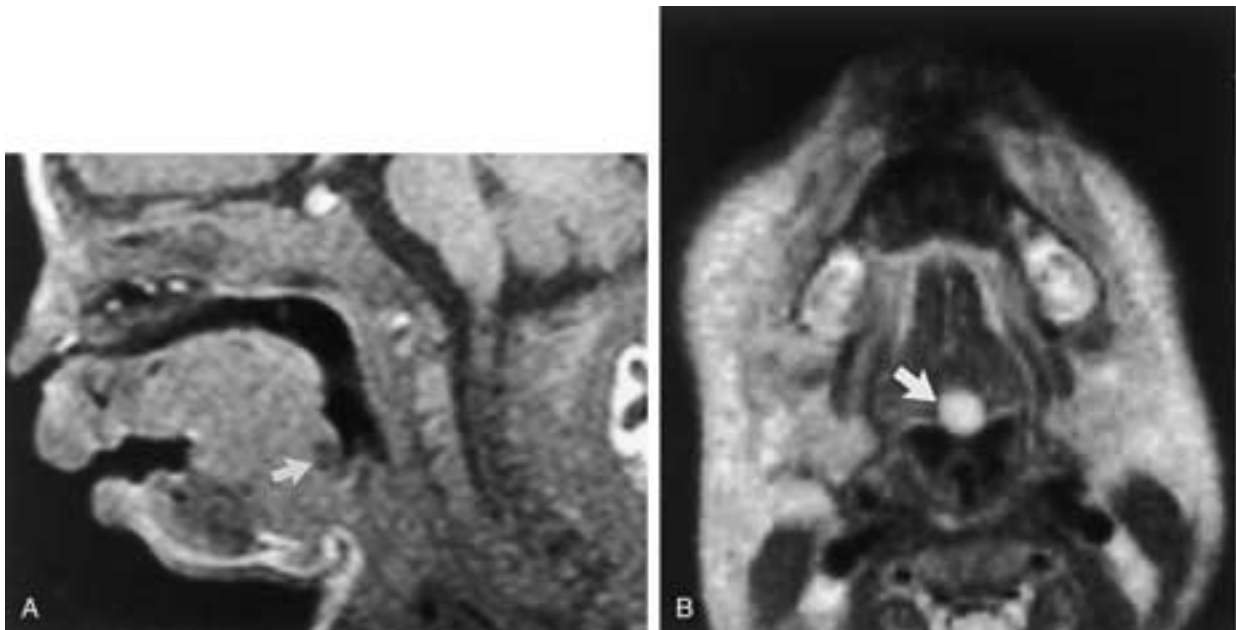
Thyroglossal duct cyst at the foramen cecum in a neonate. (A) Sagittal T1-weighted and (B) axial T2-weighted MR images demonstrate a small lesion with cystic characteristics in the midline of the tongue base at the site of the foramen cecum (arrows).
